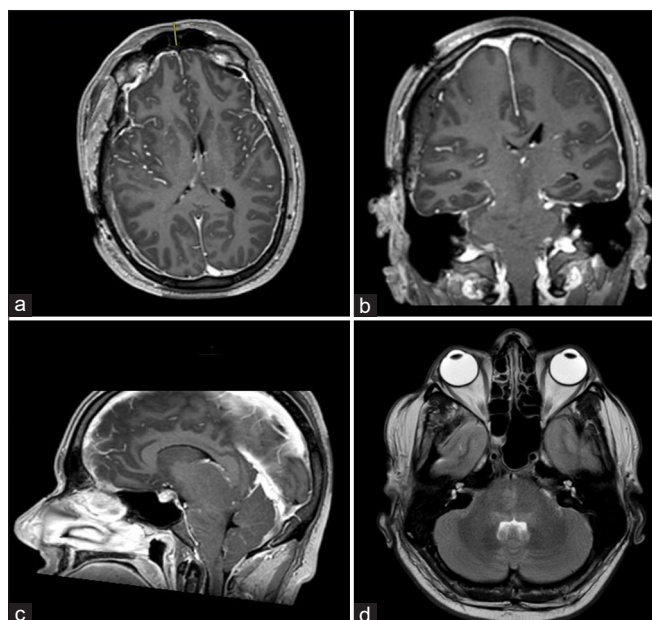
Magnetic Resonance Imaging (MRI) brain showing (a and b) pachymeningeal thickening bilaterally, (c) cerebellar tonsillar herniation, pituitary congestion, flattening of pons, and (d) high T2 signal in the right hemipons indicative of acute infarct.
